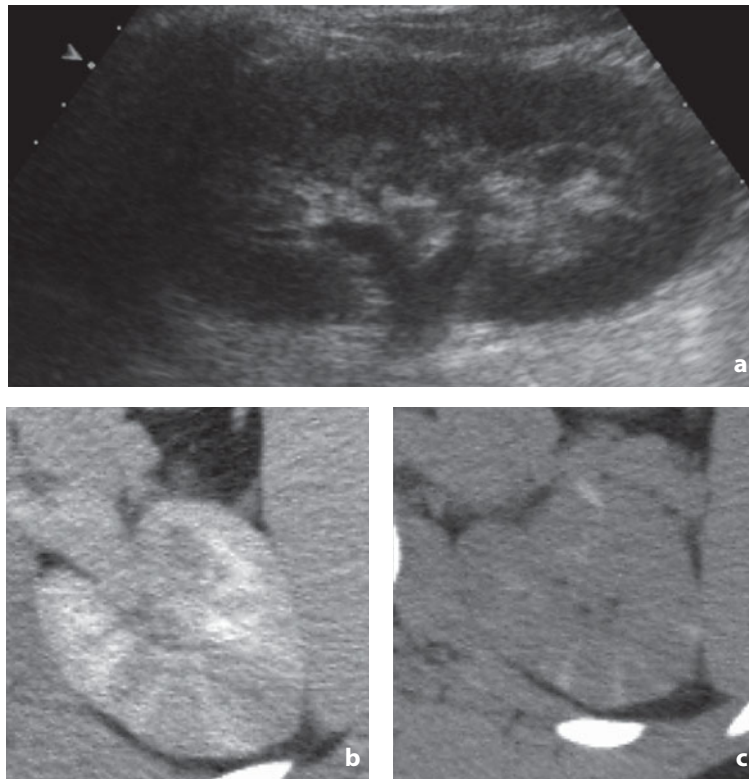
Ultrasonography and contrast-enhanced CT. Acute diffuse pyelonephritis. a The US study of the kidney shows a moderate increase in parenchymal thickness. b At CT in the nephrographic phase the areas affected by pyelonephritis appear as hypoattenuating wedge-shaped areas with ill-defined margins. c In the delayed images, acquired 3 h after contrast medium injection, some of the areas show nonuniform contrast medium uptake (delayed nephrogram)
